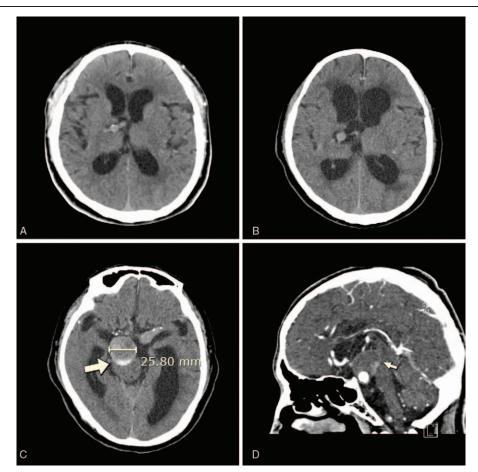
CT scan of the brain 2 years later (A) compared with initial CT (B). The frontal horns of both lateral ventricles and periventricular low densities were larger. The diameter of the ectatic basilar artery increased to 26 mm (C), and the right optic tract near the diencephalon was compressed (arrow). Sagittal CT scan (D) showed thrombosed and expanded ecstatic basilar artery compressed at the midbrain, resulting in obstructed cerebrospinal outflow at the cerebral aqueduct level. CT = computed tomography.
